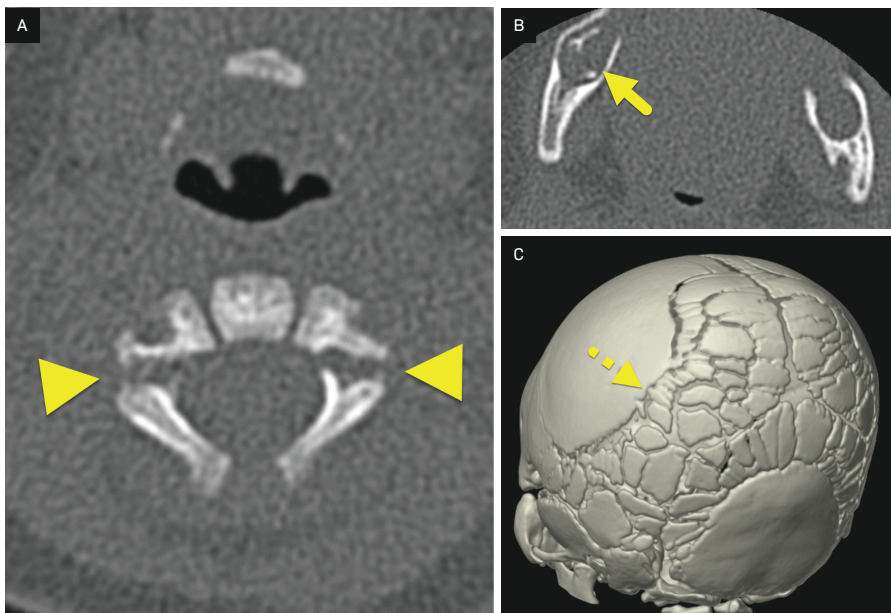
(A) Axial CT image through the C2 vertebral body showing a fracture of both pedicles (arrowheads). (B) Axial CT image through the mandible showing the absence of the normal lamina dura surrounding the teeth (arrow). (C) 3-dimensional reconstruction of the skull showing multiple Wormian bones (dashed arrow).
